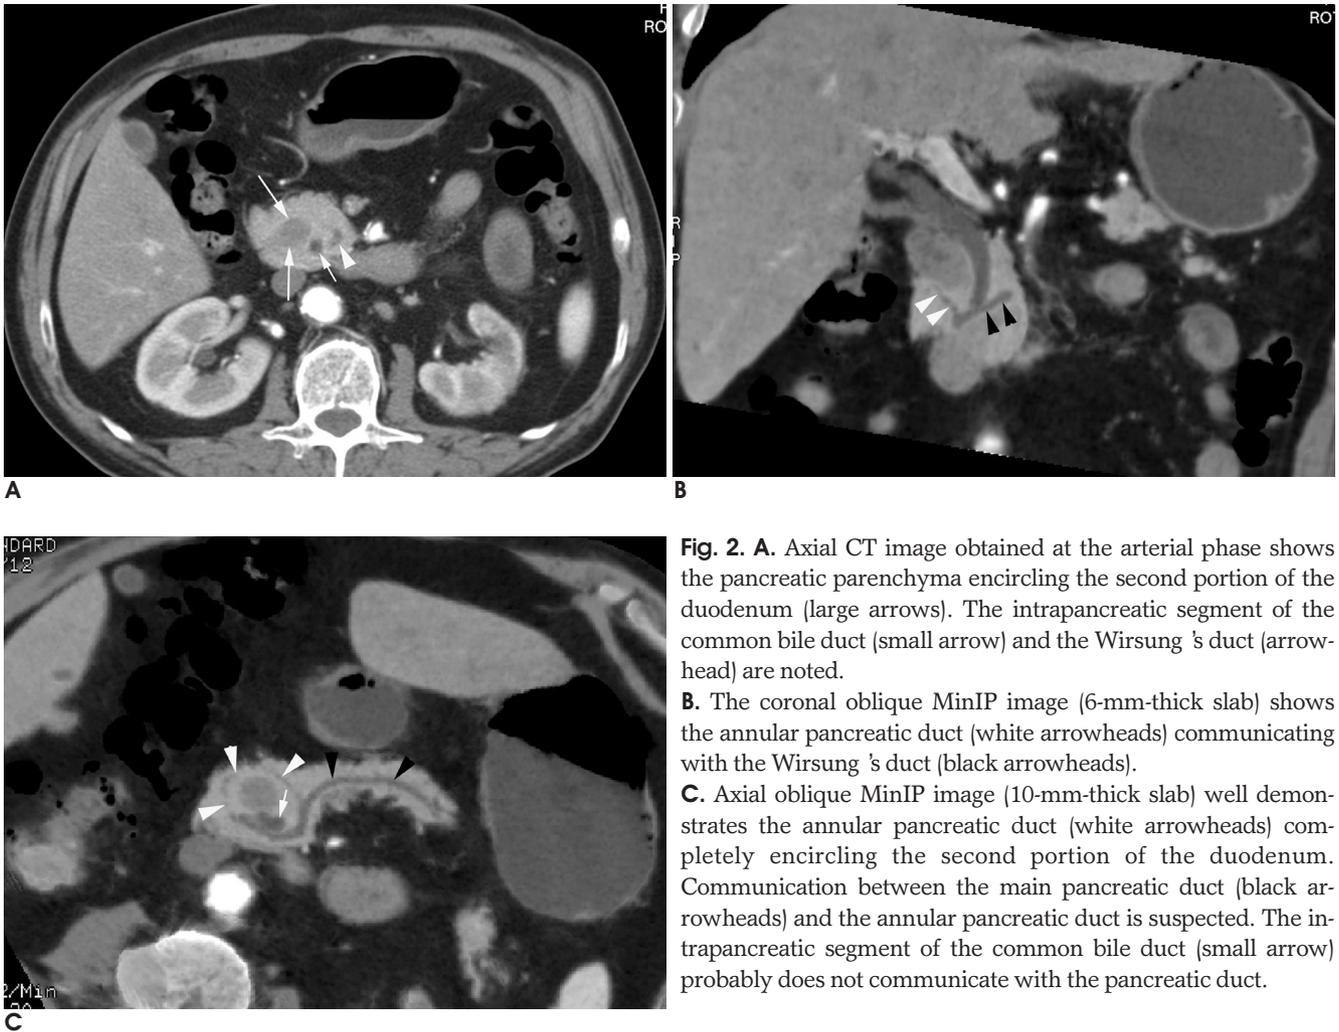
A. Axial CT image obtained at the arterial phase shows the pancreatic parenchyma encircling the second portion of the duodenum (large arrows). The intrapancreatic segment of the common bile duct (small arrow) and the Wirsung's duct (arrowhead) are noted. B. The coronal oblique MinIP image (6-mm-thick slab) shows the annular pancreatic duct (white arrowheads) communicating with the Wirsung's duct (black arrowheads). C. Axial oblique MinIP image (10-mm-thick slab) well demonstrates the annular pancreatic duct (white arrowheads) completely encircling the second portion of the duodenum. Communication between the main pancreatic duct (black arrowheads) and the annular pancreatic duct is suspected. The intrapancreatic segment of the common bile duct (small arrow) probably does not communicate with the pancreatic duct.
